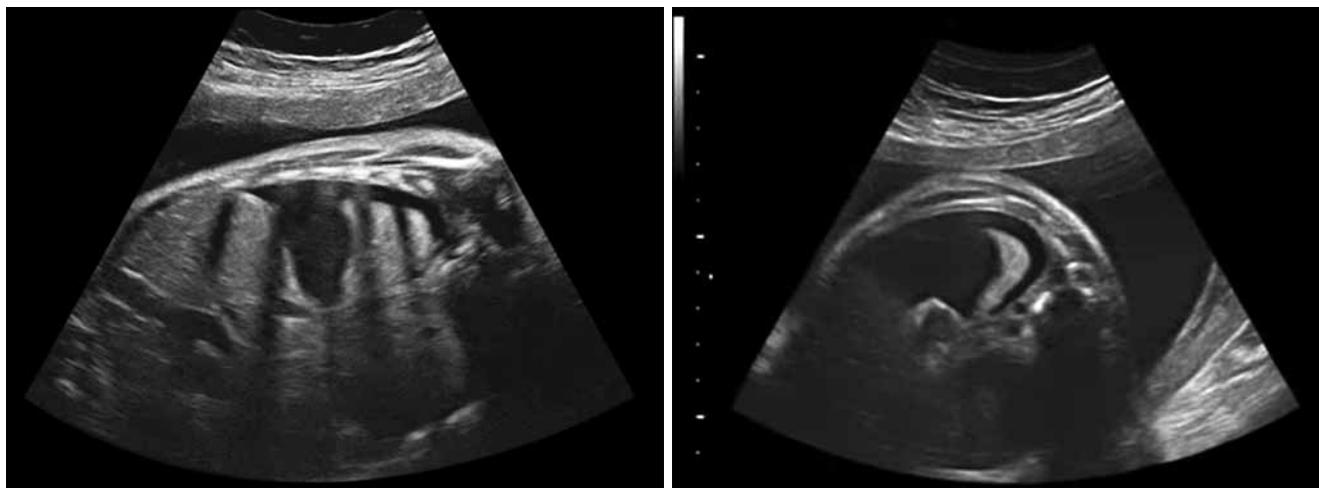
Fetal ultrasound performed at 29 weeks of gestation
